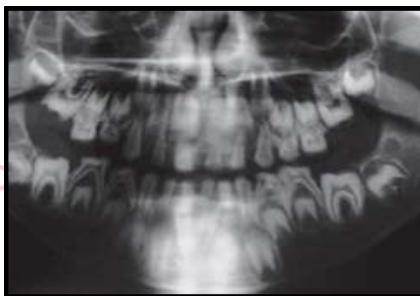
Panoramic radiograph showing absent or very thin enamel in this form of amelogenesis imperfecta.
